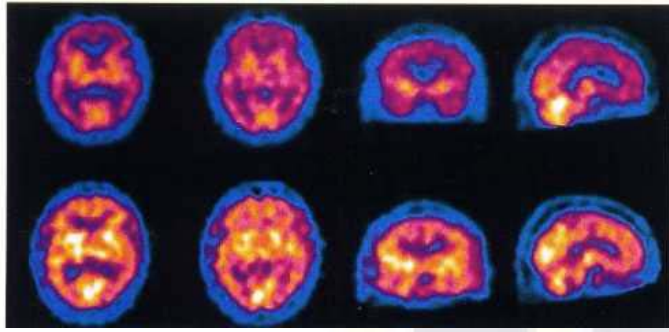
^{99m}Tc -exametazime brain SPECT: axial, coronal and right parasagittal images showing *very* extensive perfusion deficits during the acute ischaemic phase (top row) and substantial improvement several months later after clinical recovery (bottom row).
